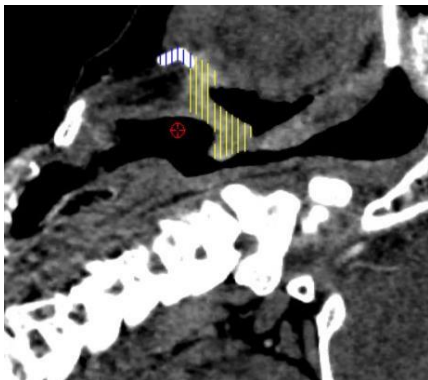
Patient A: planning CT.
